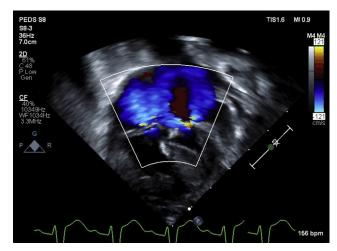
Apical four-chamber sweep with color obtained upon readmission shows severe left AV valve regurgitation through three jets. The mechanism of the regurgitation is not clear (Video 1).
